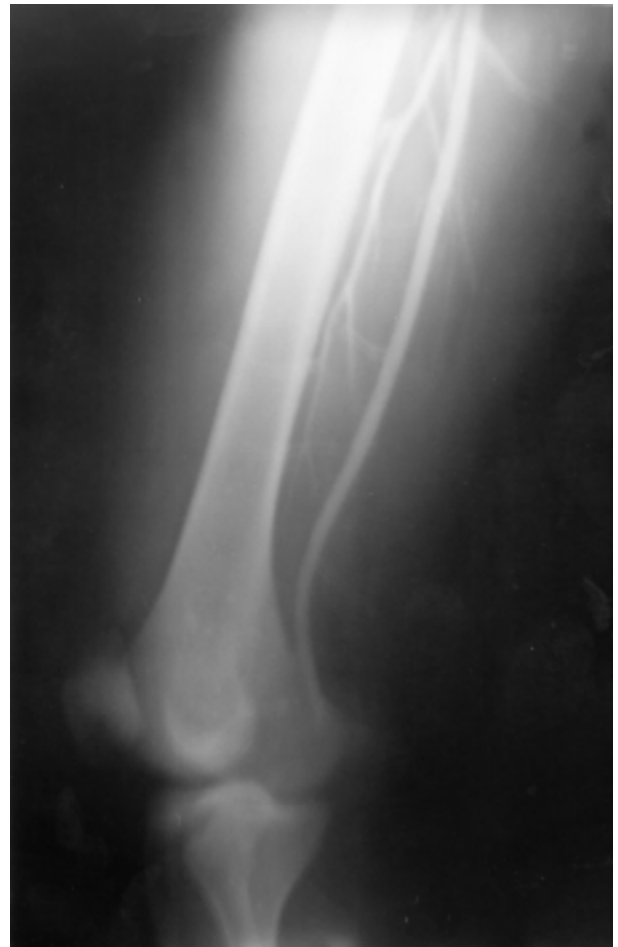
Popliteal artery injury after a knee dislocation (xray after closed reduction).
